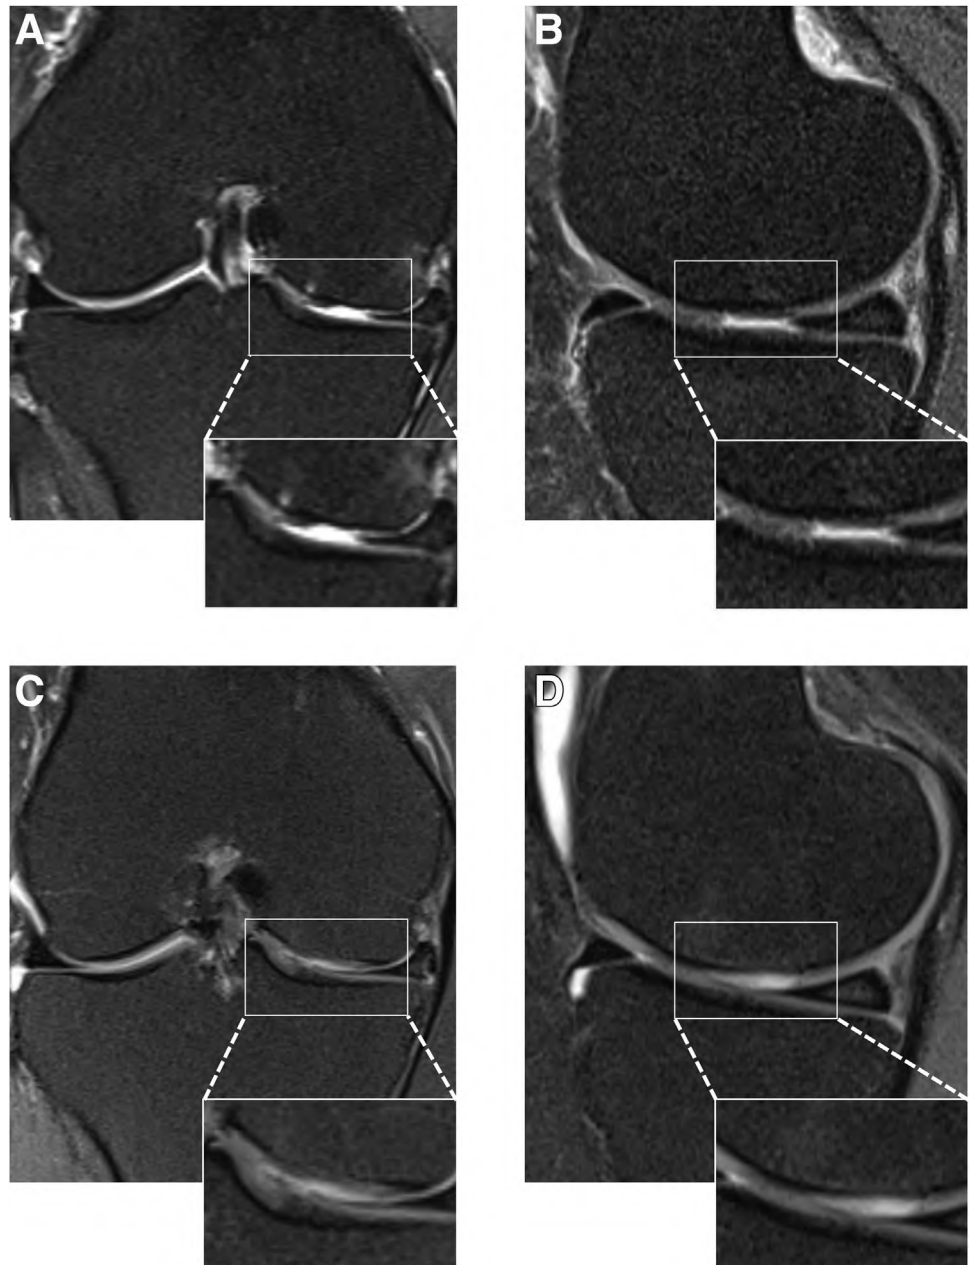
Proton-density weighted magnetic resonance images (coronal and sagittal view) of a patient with a cartilage defect of the right medial femur condyle (A) and (B) before and (C) and (D) 24 months after therapy with Novocart inject.
